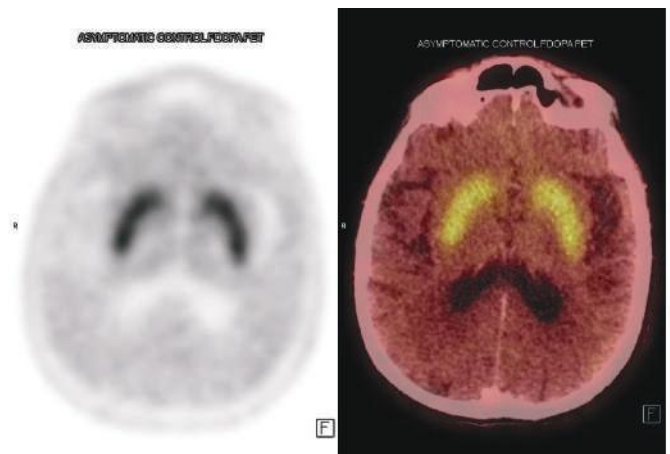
F-18 Fluorodopa PET CT scan of the brain in an asymptomatic elderly male showing symmetrical radiotracer uptake in bilateral basal ganglia.
